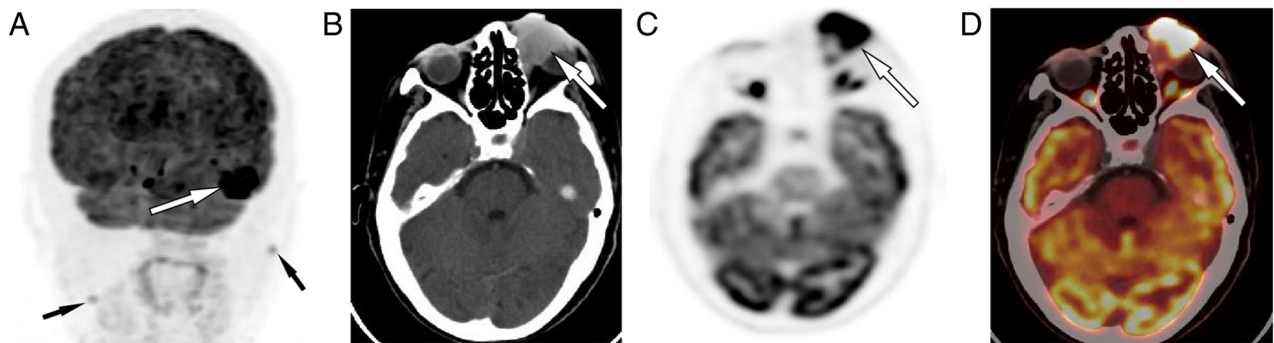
(A) The maximum intensity projection map showed a lesion with intense ^{18}F -FDG uptake in the left ocular region (white arrow). Moreover, additional ^{18}F -FDG nodules with mild uptake were apparent bilaterally in the neck (black arrows), which were later pathologically confirmed to be inflammatory. (B) Axial CT showed the shadowing of the left ocular region as a homogeneous slightly hyperdense mass (white arrow). (C) Axial PET and (D) PET/CT fusion showed strong uptake of ^{18}F -FDG in this lesion, with a maximum standardized uptake value of 12.8 (arrows). ^{18}F -FDG, fluorine-18-fluorodeoxyglucose positron emission tomography; CT, computed tomography; PET, positron emission tomography.
